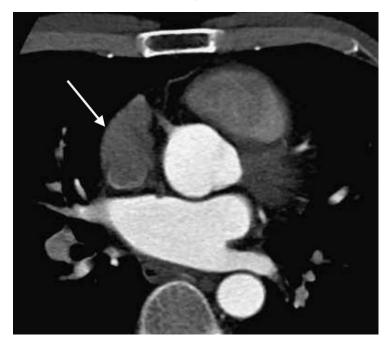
CT axial image shows typical appearance of right atrial appendage (white arrow): blunt, trapezoidal shape with a broad connection to the rest of the atrium.
